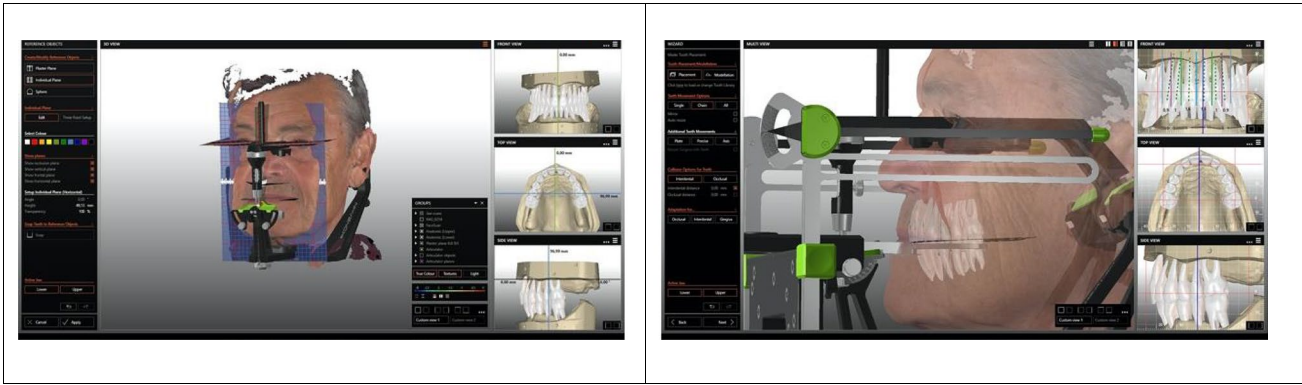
When all the necessary information from an edentulous patient is acquired (face scans, scans of edentulous jaws, plane positioner, plane finder, digital photographs, dental casts, and CBCT data), the different parts are superimposed, aligned, and matched leading to a virtual patient, who is anytime available. Denture teeth are selected
